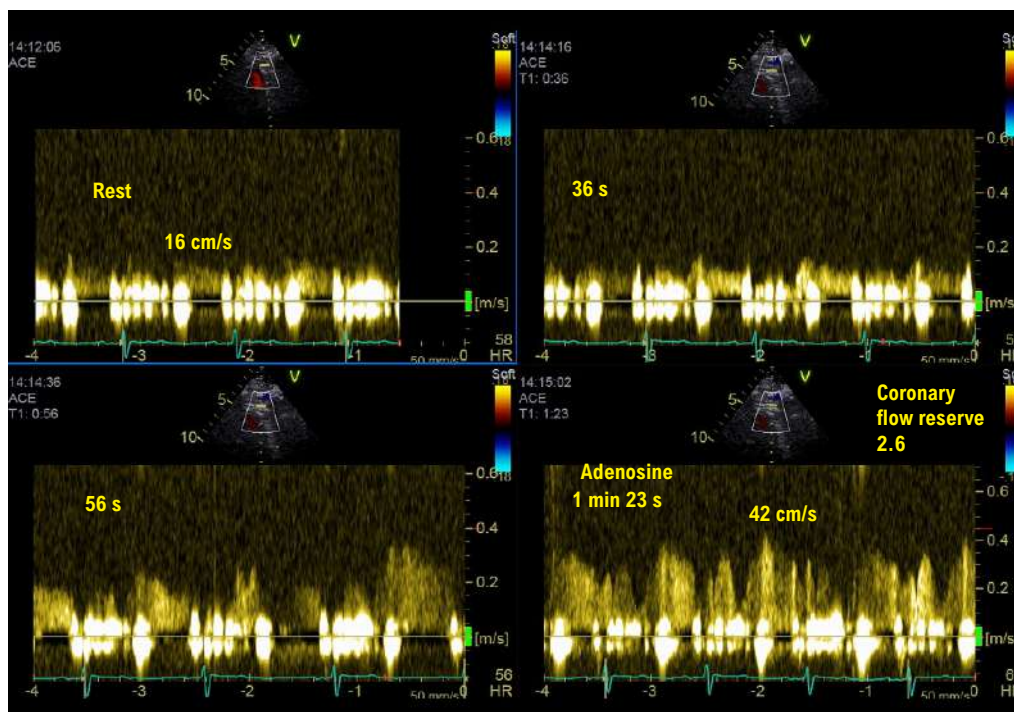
The use of adenosine in stress echocardiography demonstrates the major contribution of the vasodilatory effect in increasing coronary flow reserve (CFR), with a progressive, significant increase during the examination seen after 1 minute 23 seconds of adenosine infusion. The CFR increased from 16 cm/s at rest to 42 cm/s.
